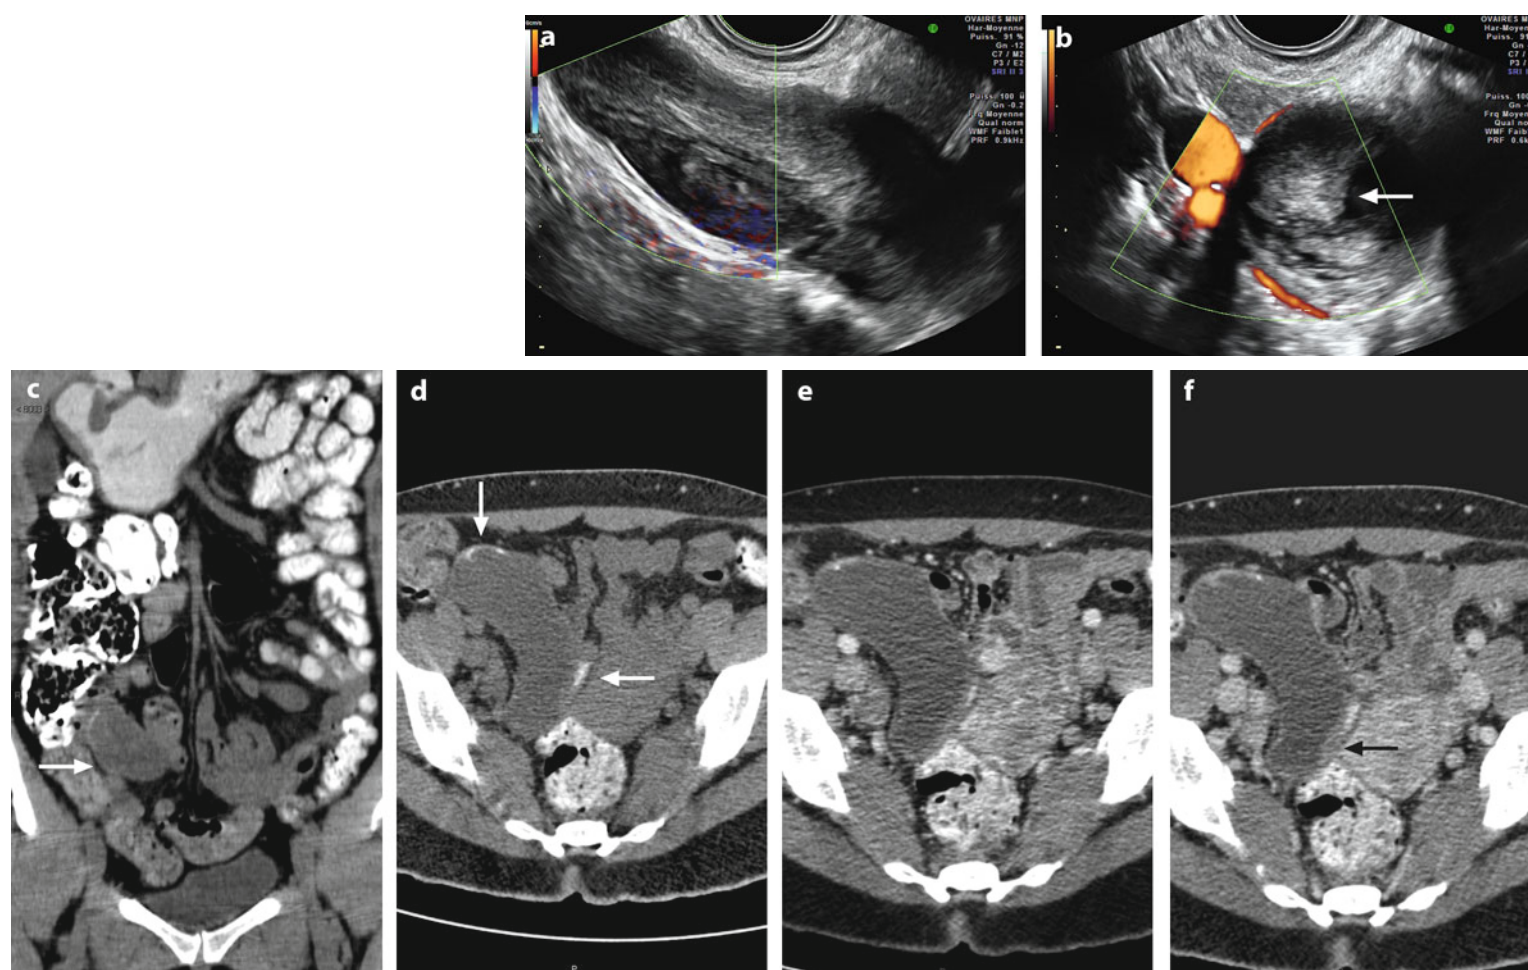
Borderline mucinous tumor of the appendix. Forty-five-year-old woman. Right pelvic pain and sensation of a mass in the right iliac fossa. EVS longitudinal (a) and transverse (b) display an echogenic tubular mass in the right iliac fossa, with a regular vessel in the wall, containing an echogenic material without color flow (arrow). Location of the mass close to the cecum and the tubular shape suggest an appendicular origin. CT without
